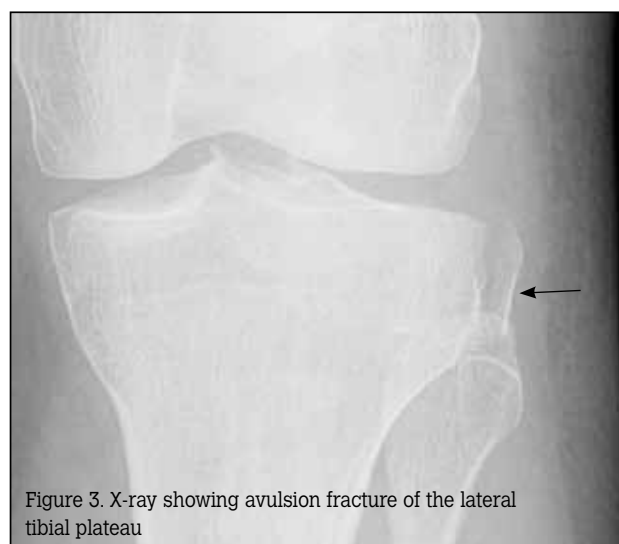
X-ray showing avulsion fracture of the lateral tibial plateau
